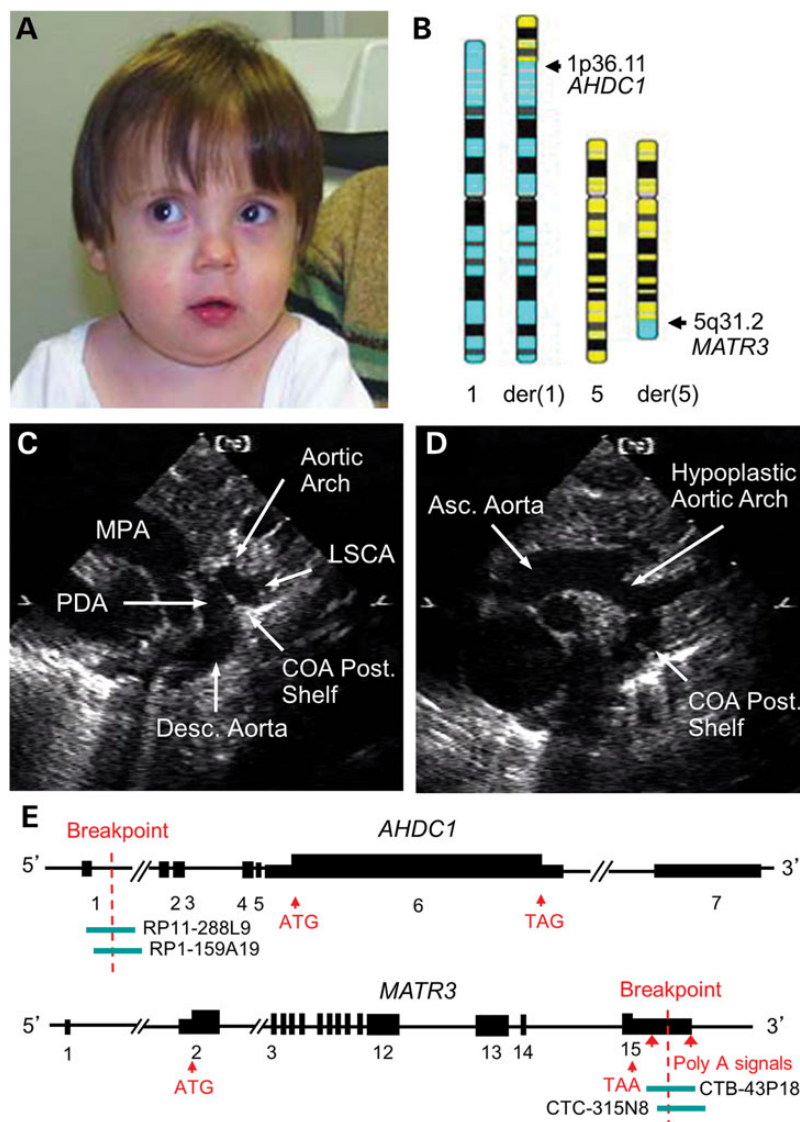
Clinical features, cardiac phenotype and translocation breakpoint structure in DGAP105. (A) Facial features at 4 years of age included mild hypertelorism, bilateral epicanthal folds, downslanting palpebral fissures, strabismus and a broad nose with a smooth philtrum and thin vermilion border. (B) Ideograms depicting 46,XY,t(1;5)(p36.11;q31.2)dn. Arrows mark locations of *AHDC1* and *MATR3* breakpoints. (C and D) Echocardiograms at age of 2 days. (C) Ductal view showing distal aortic arch, CoA just distal to the left subclavian artery (LSCA), accompanied by a prominent posterior unfolding ('posterior shelf') and PDA. (D) Aortic arch view showing ascending aorta (5.7-mm diameter), hypoplastic aortic arch (4.4-mm diameter) and CoA posterior shelf. (E) Summary of the 1p36.11 and 5q31.2 breakpoints in DGAP105. The 1p36.11 breakpoint disrupts *AHDC1* intron 1, whereas the 5q31.2 breakpoint disrupts *MATR3* exon 15 in the 3' UTR. BACs used in FISH analyses are indicated.
